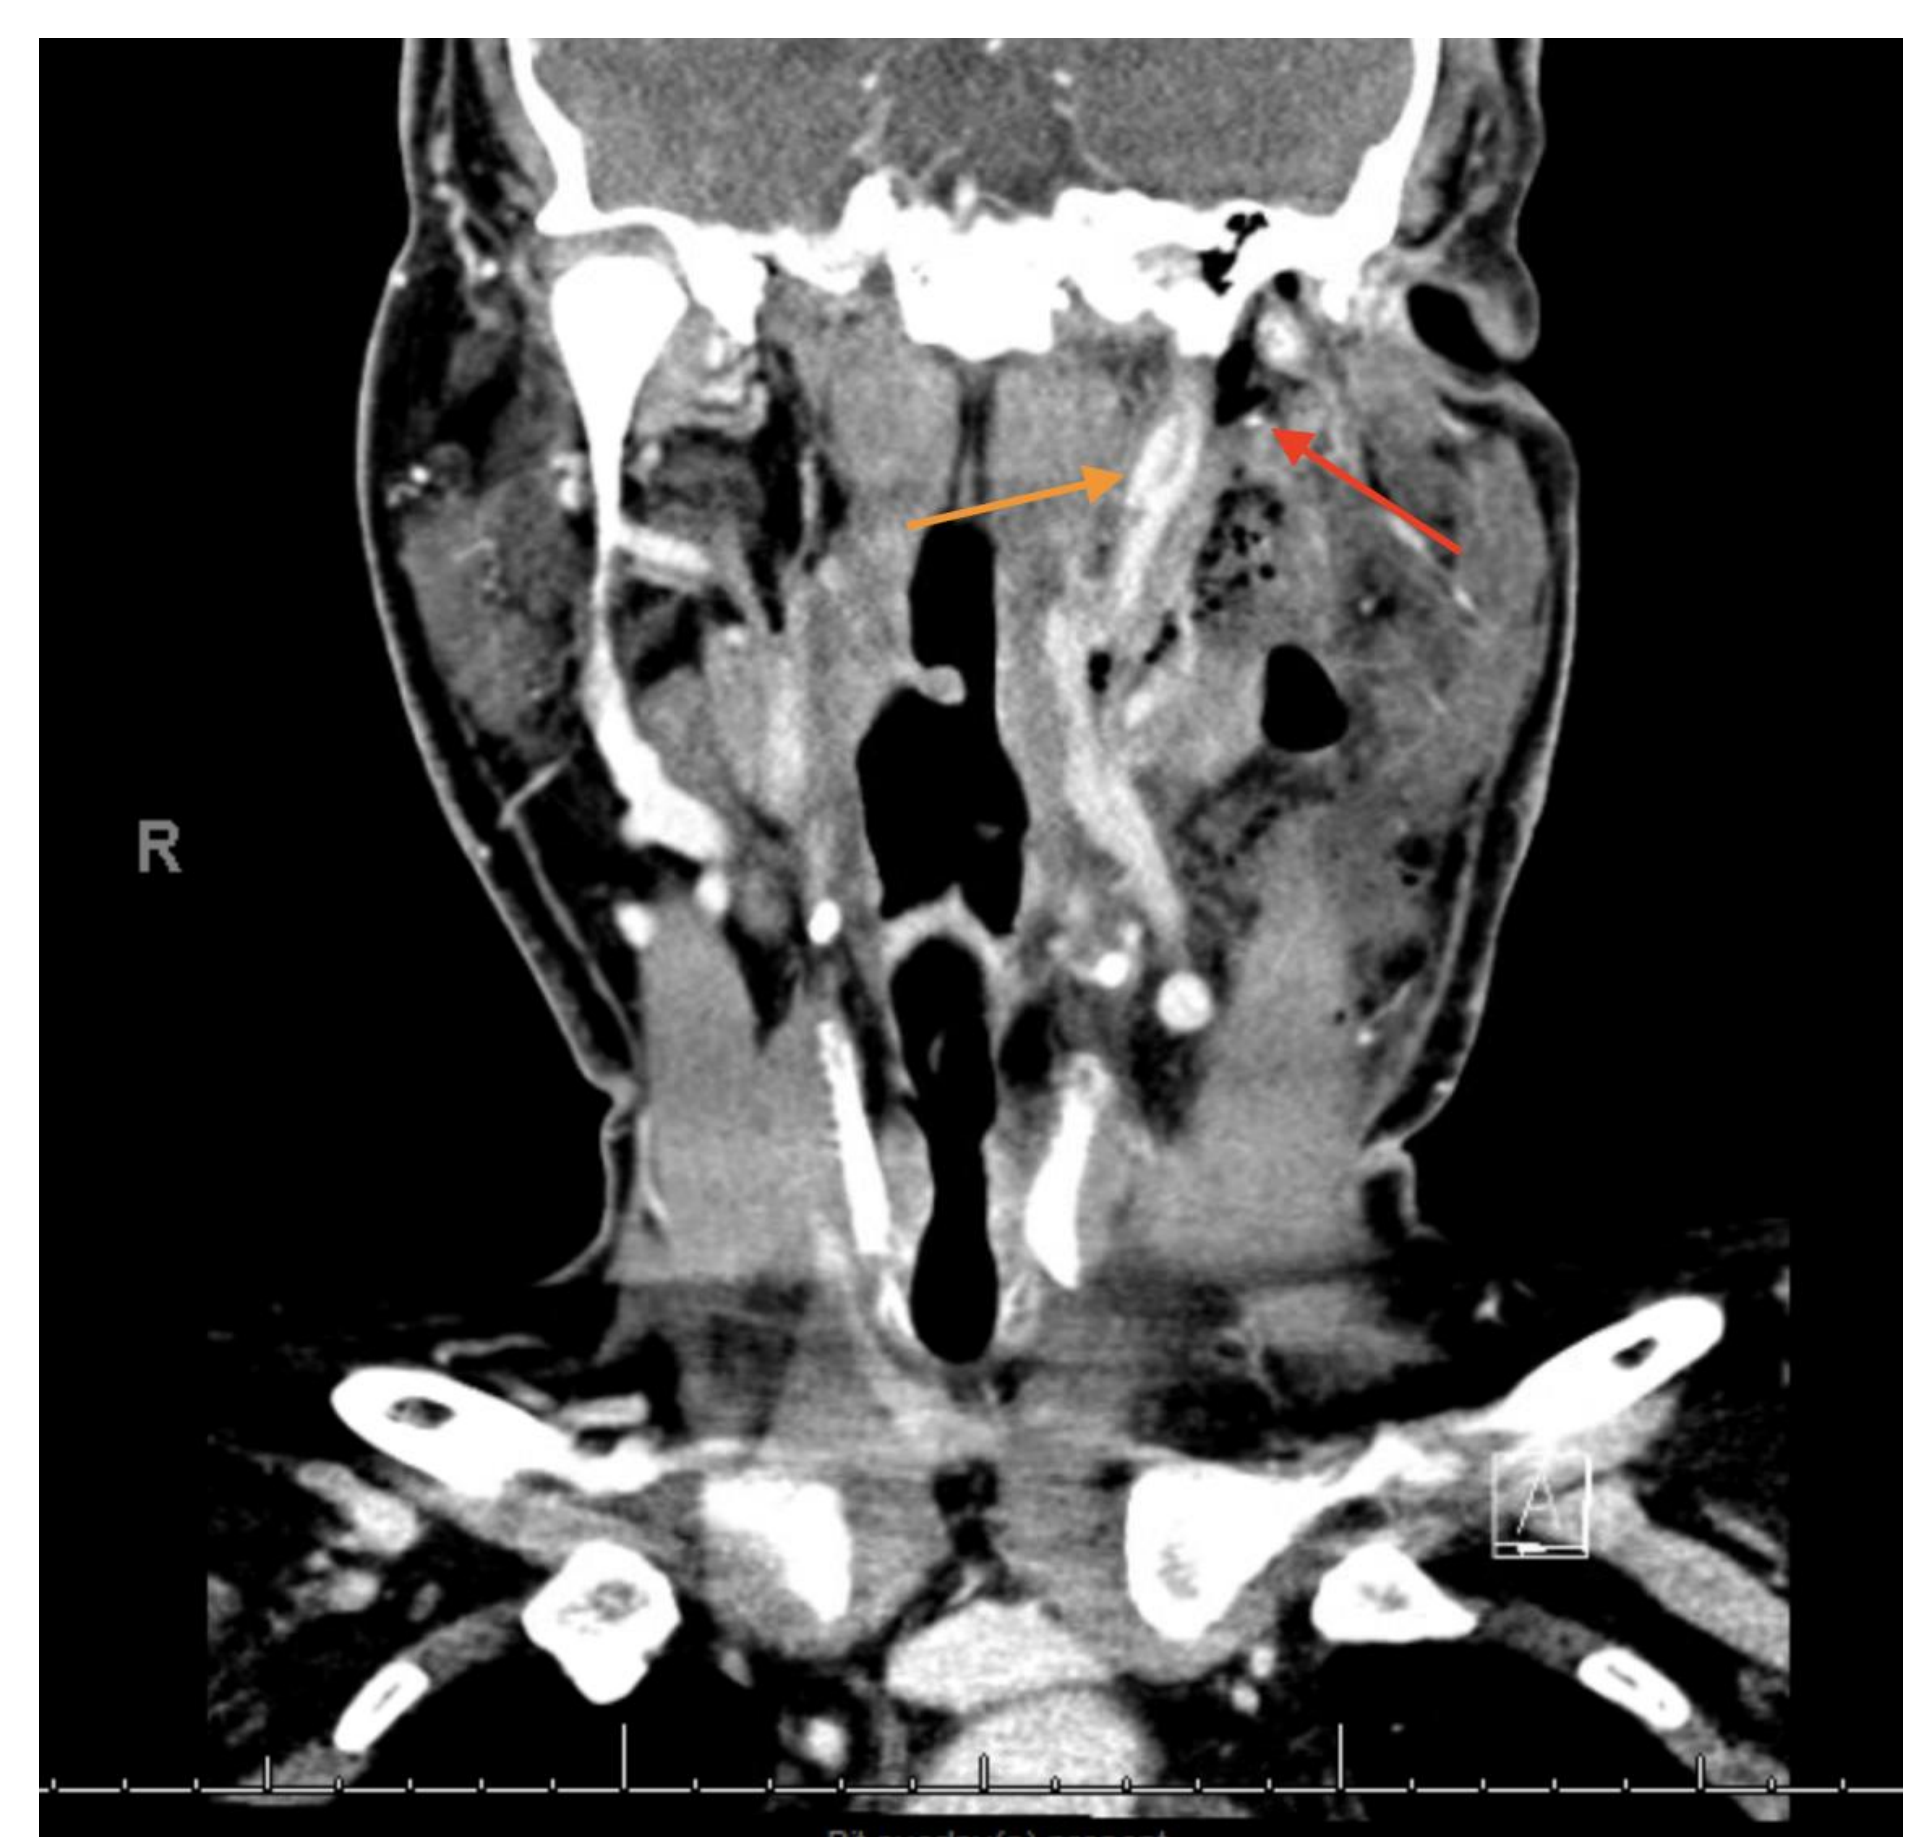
Post-op Coronal CT Angiography of the Neck, bone window. Distal aspect of remaining left styloid (red arrow) now separated from pseudoaneurysm (orange arrow)
